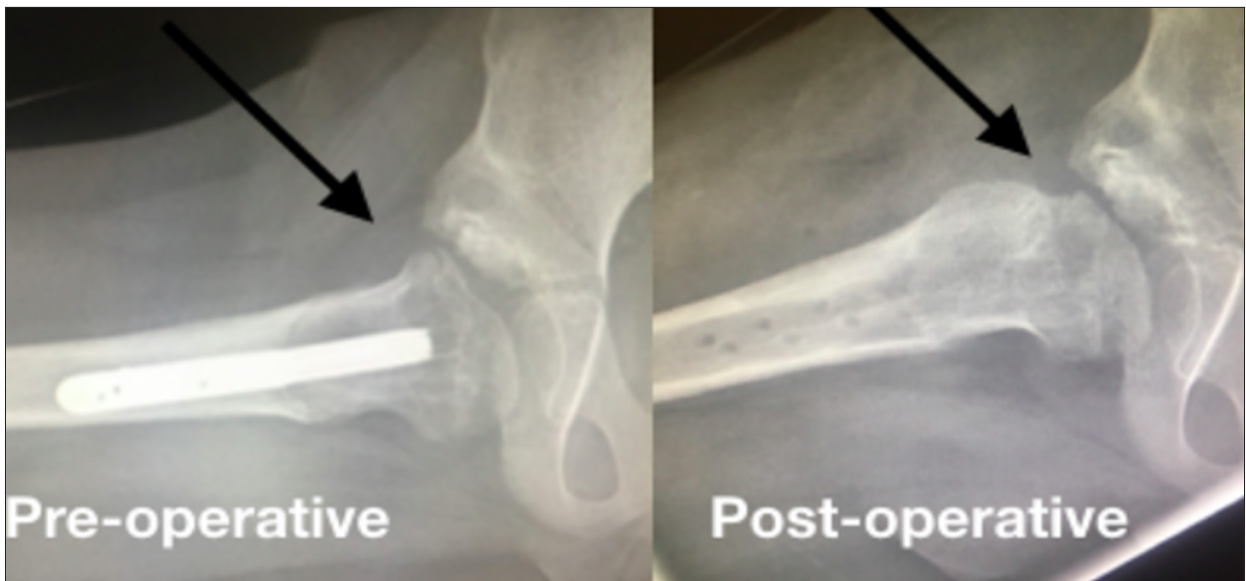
Pre-operative and post-operative X-ray (Lauenstein view) after plate removal, hip arthroscopy, and resection of CAM in our 7-year-old patient. The arrow shows the location of the CAM that no longer exists after hip arthroscopy.
